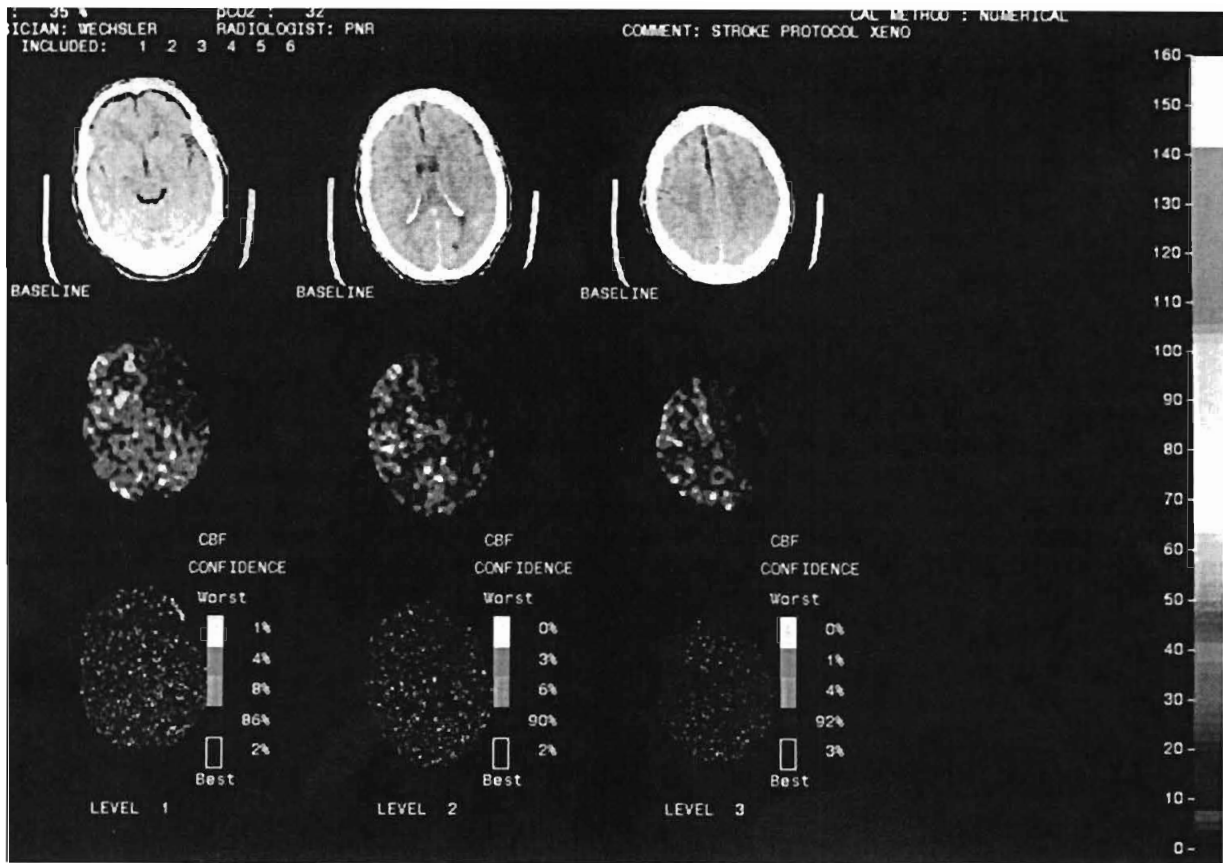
Xenon computed tomography blood flow study from a patient with large left hemisphere stroke 3 hours after onset of symptoms. Flow is nearly absent throughout the middle cerebral artery territory on the left.
